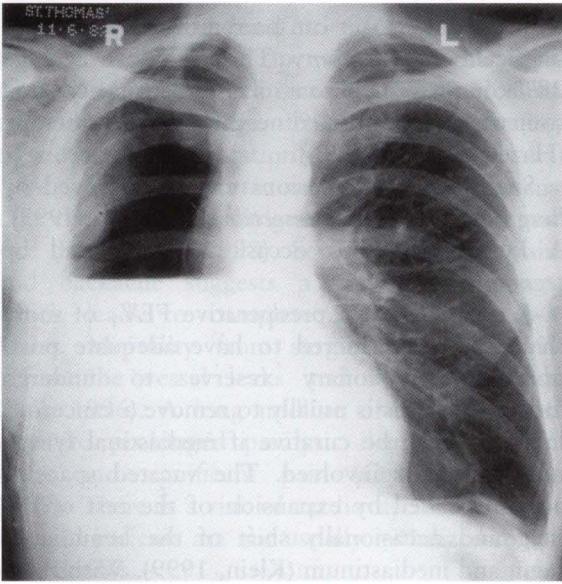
X-ray one day after right pneumonectomy, showing a horizontal fluid line separating the exudate from the air-filled space, which shows no lung markings. The trachea is shifted towards the vacated space. Speckled appearance in the soft tissue outside the rib cage on the right is surgical emphysema.
